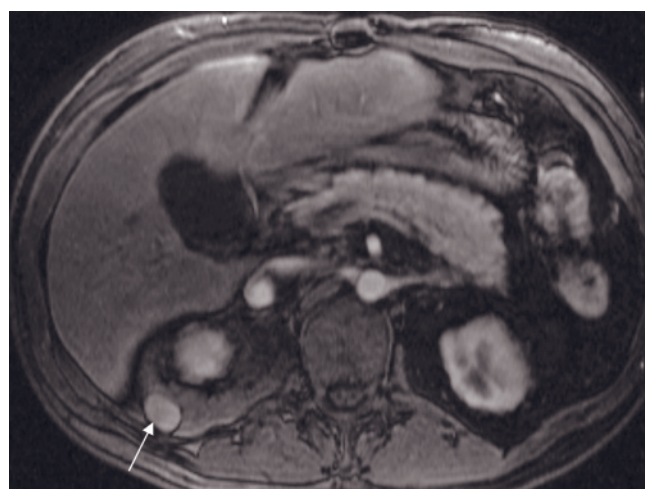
(Continued) 90-s postgadolinium T1-weighted fat-suppressed SGE (*b*) images in a second patient with prior splenectomy. Two splenules are present in the left upper abdomen (arrows, *d*). The masses have an appearance similar to normal spleen, with mild hypointensity on T1 (*d*), moderate hyperintensity on T2 (*e*), and early heterogeneous enhancement (*g*), which becomes more homogeneous on delayed images (*h*). Note that the enhancement of the larger mass is less than that of the smaller mass, presumably reflecting a smaller feeding arterial supply. T1-weighted fat-suppressed immediate (*i*) and delayed (*j*) postgadolinium 3D-GE images at 3.0 T show an enhancing mass (arrows) consistent with splenosis in another patient with prior splenectomy. The mass shows serpiginous enhancement pattern on immediate postgadolinium 3D-GE image (*i*) and homogenous enhancement on postgadolinium delayed 3D-GE image (*j*). T1-weighted fat-suppressed immediate postgadolinium 3D-GE images (*k*, *l*, *m*) show
